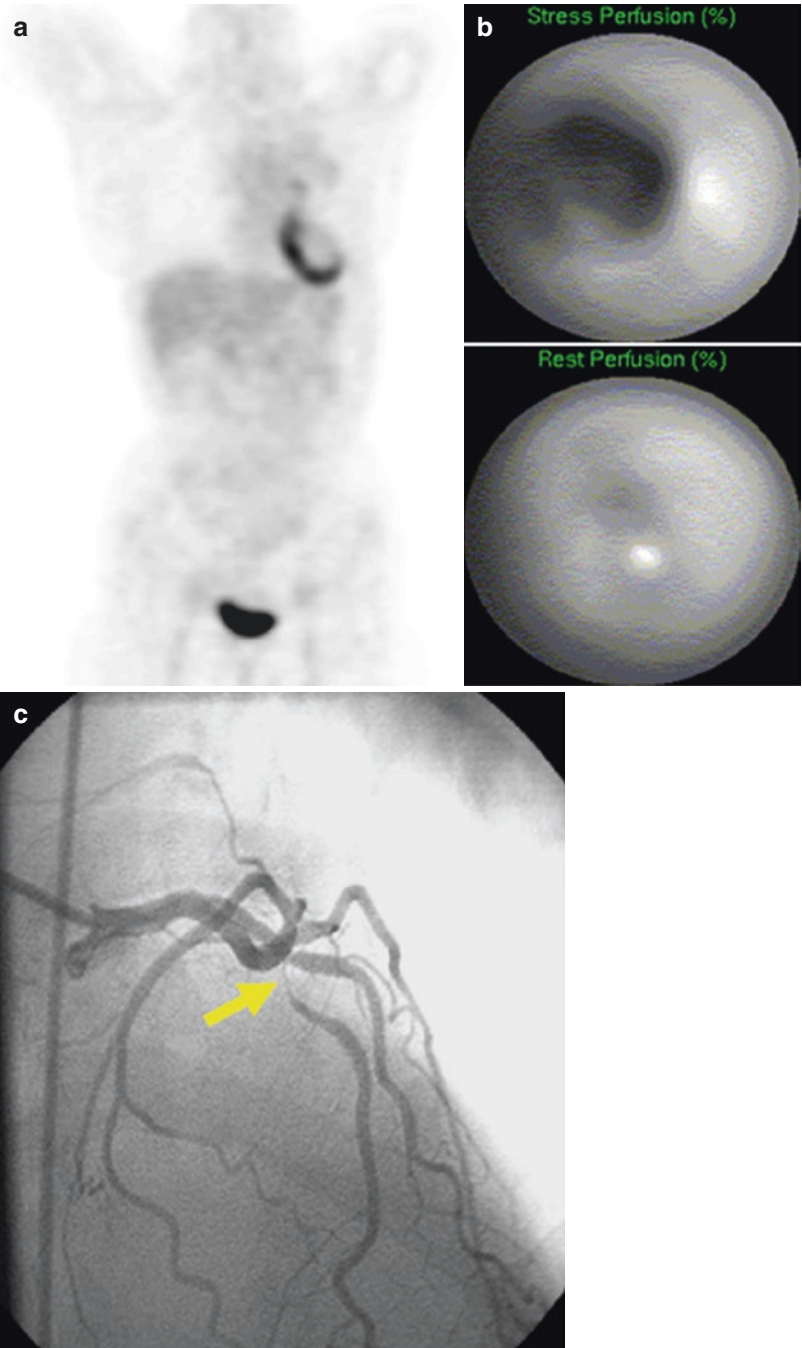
Myocardial ischemia detected by FDG-PET. A patient with non-Hodgkin's lymphoma undergoing whole-body FDG-PET imaging for detection of recurrence. (a) Images acquired under fasting conditions demonstrate localized uptake in septal, anterior, and inferior walls of the myocardium, suggestive of either ischemia in these walls or infarction of the lateral wall. (b) Rest/stress SPECT myocardial perfusion imaging demonstrates inducible ischemia in the same distribution as the FDG uptake. (c) Coronary angiography demonstrates a high-grade stenosis in the left anterior descending artery (yellow arrow)
